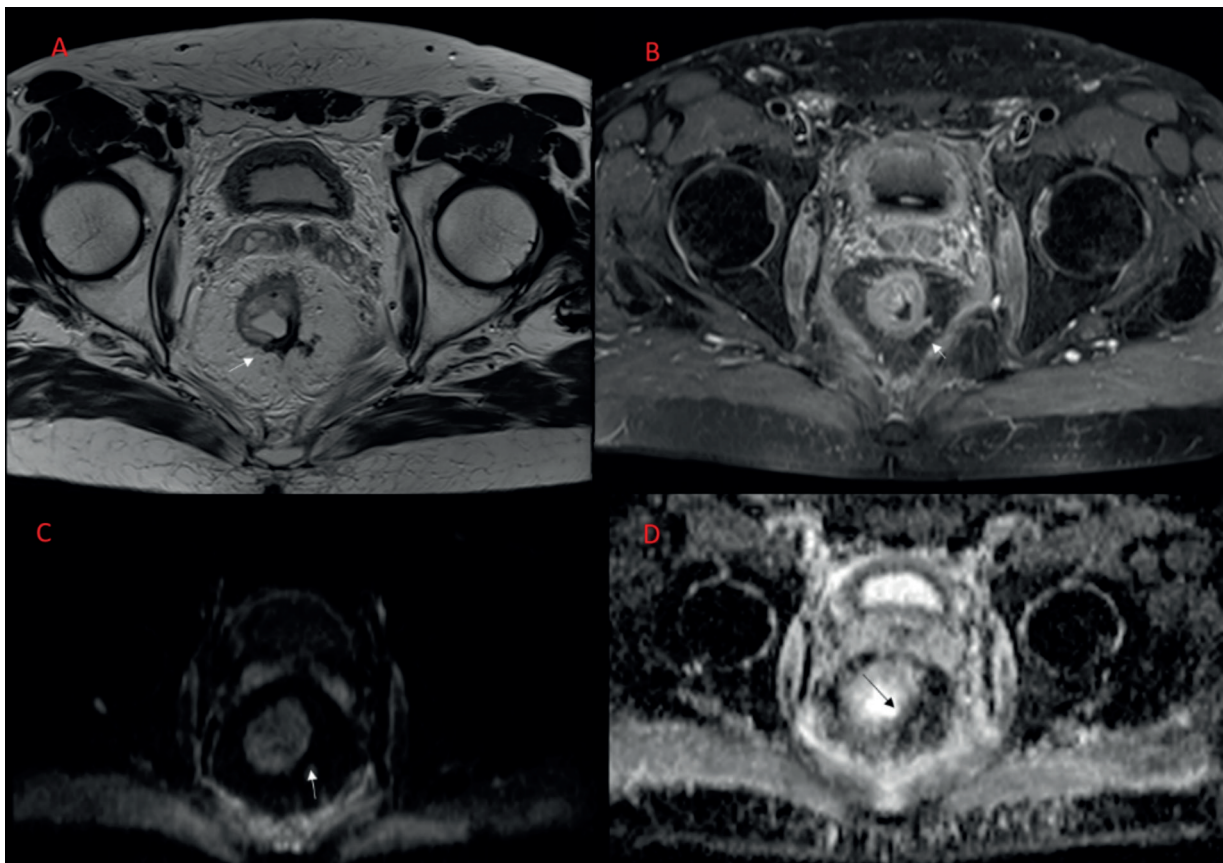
Post treatment rectal cancer: complete response with fibrotic residual tissue that shows hypointense signal in T2-W sequence (A), no contrast enhancement (B) (ce MRI), no restricted signal in diffusion (C: b 800 s/mm²). In D ADC map.
